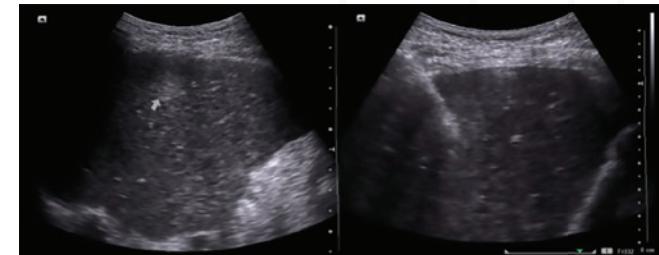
Ultrasound images during liver biopsy. In the left image the white arrow shows the faintly visible needle tip, and right image shows the length of the needle more clearly.
